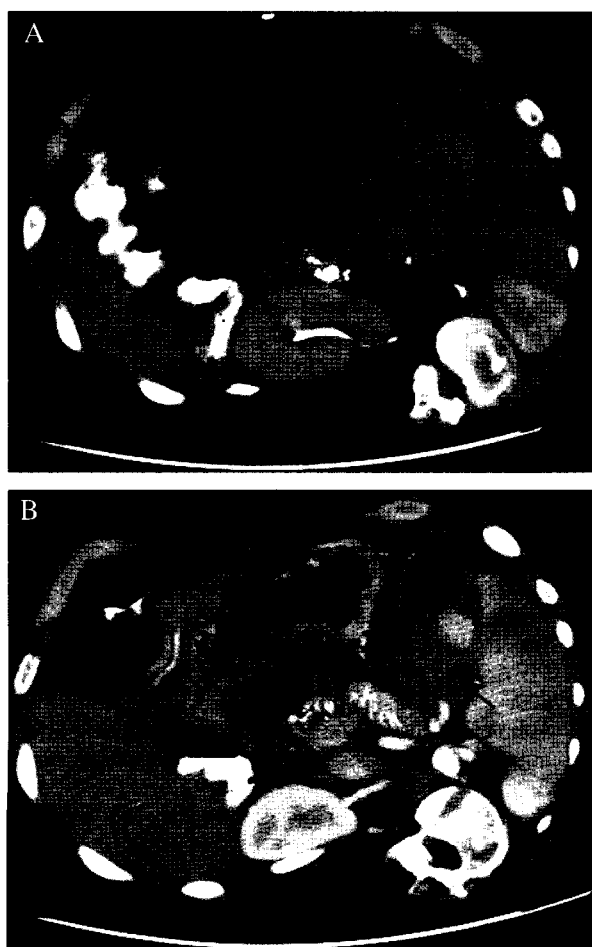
(A) CT without contrast reveals heterogeneous peri-splenic hilar mass (arrow), which is about 93×62 mm in size. (B) Contrast CT shows enhancement of a 48×38 mm aneurysm with peripheral hematoma (arrows).
